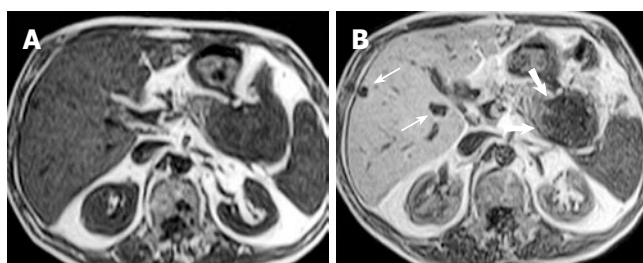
T1-weighted axial SE contrast-unenhanced (A) and MnDPDP-enhanced (B) images of pancreatic adenocarcinoma with liver metastases. MnDPDP enhancement was not determined in the lesion while the normal parenchyma of the pancreas showed homogeneous contrast enhancement. MnDPDP-enhanced image showed the better delineation of the tumor (thick arrows). Tiny liver metastases (thin arrows) were not determined on unenhanced MR image but on MnDPDP-enhanced MRI.
